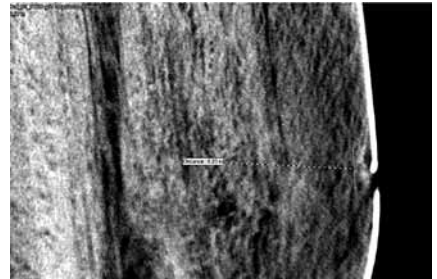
CT scan of cell 5 showing breach in case.
